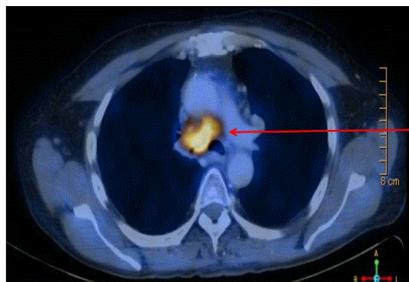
Baseline PETCT scan showing FDG avid right upper lobe perihilar lesions, mediastinal lymphadenopathy.
